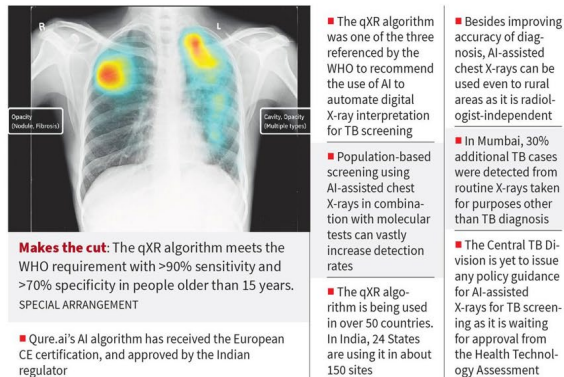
Shows Chest X-ray interpretation using AI published in - The Hindu Prasad (2023)
